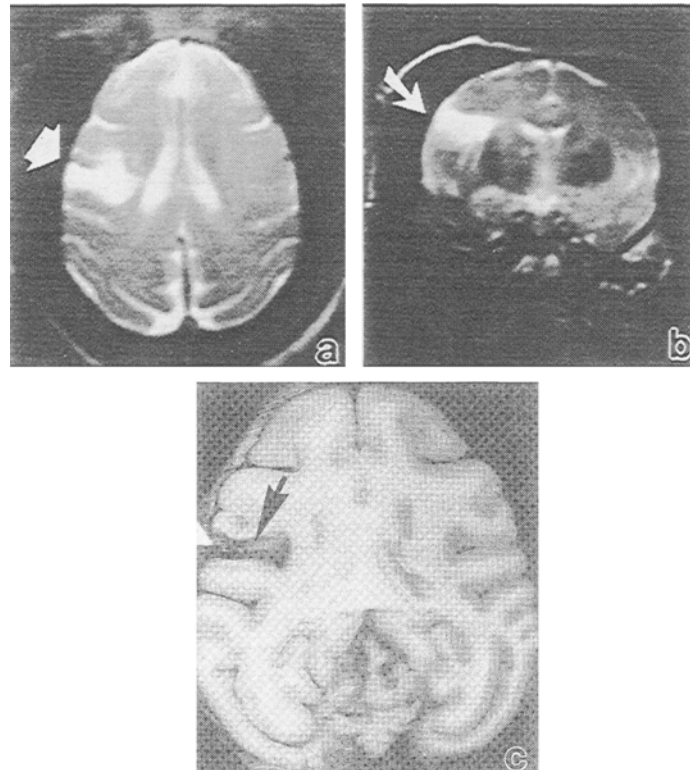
Magnetic resonance images (T-2 dependent, Tr, repetition rate=2000 msec, and TE, echo time=90msec, using a GE scanner, 1.5 tesla). Opaque shadows in the left lateral temporal lobe in horizontal (a, arrow) and coronal (b, arrow) planes. An area of cerebral softening in the temporal lobe of horizontally sliced brain (c, arrow) corresponds with MRI images.
